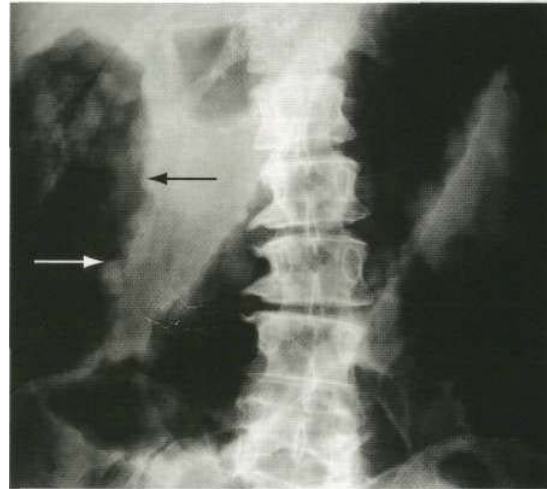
Plain abdominal X-ray, showing toxic dilatation in ulcerative colitis. The arrows indicate mucosal islands.
